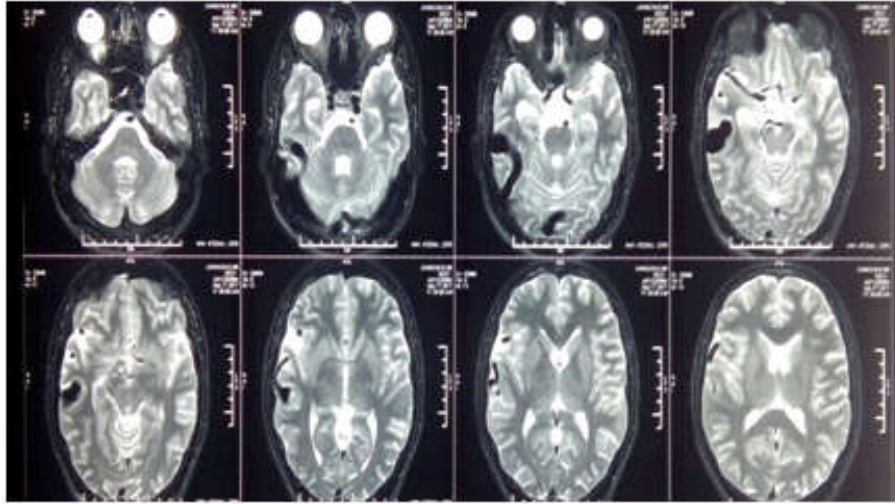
(c): T2 MRI showing the Pial Arteriovenous fistula.
